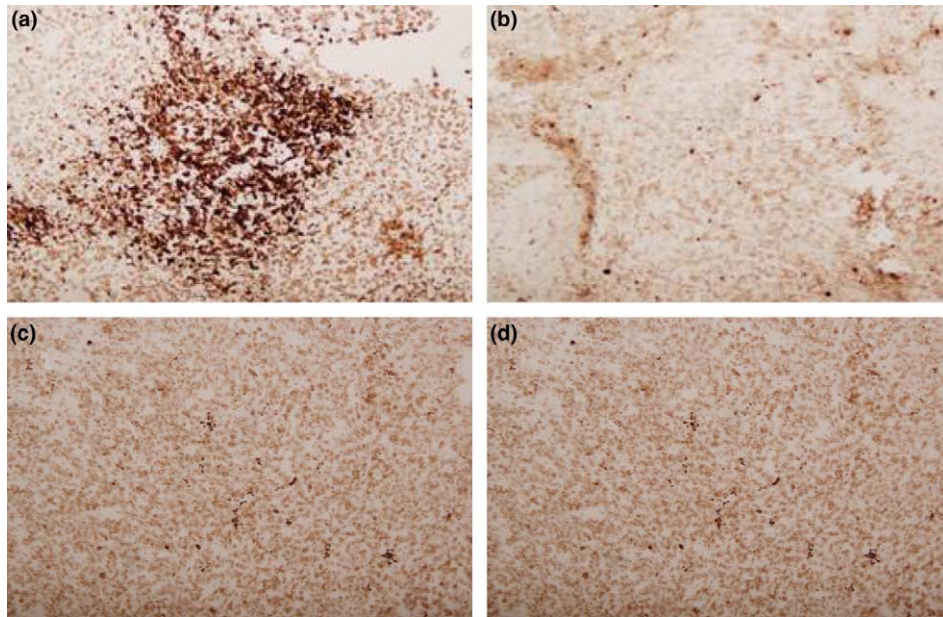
Focal areas of apoptosis induced in C26 tumour tissue after (a) 24 h after CEFUS treatment. (b) No evidence of apoptosis is seen in the untreated control (c) or in tumours treated by ultrasound (d) or by electric field alone after 24 h.
